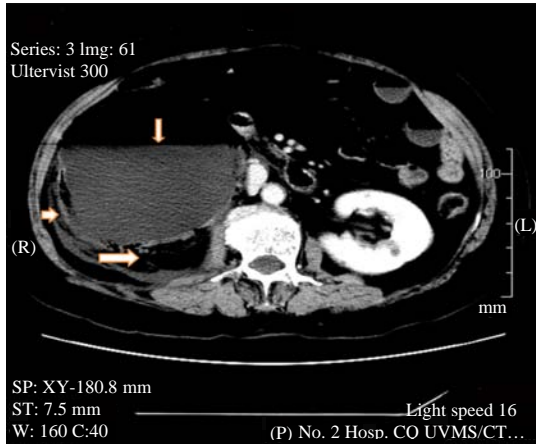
(Case 1) Computed tomography of the abdomen revealed the original left kidney region replaced by a huge sac filled with a mass of gas and fluid. Severe hydronephrosis and the gas-fluid interface (long narrow arrow) can be seen, Gerota's fascia was inflamed (short broad arrow) and thickened
